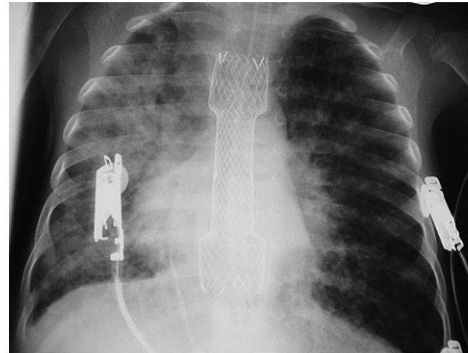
Chest radiograph demonstrating the placement of a stent in the oesophagus of a child with a broncho-oesophageal fistula.
